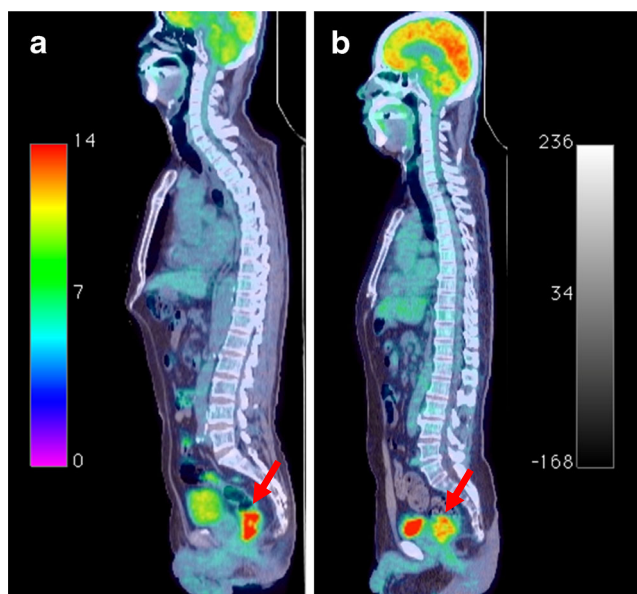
Representative pretreatment [^{18}F]FDG PET/CT images. a A 75-year-old man with cT3N2M0 rectal cancer who had undergone nRCT with capecitabine. After surgery, the pathological stage was ypT3N1M0 with a negative circumferential resection margin and perineural involvement. He received adjuvant chemotherapy, and showed no evidence of disease for 21 months after initial diagnosis. The PET/CT image shows a primary rectal cancer lesion with homogeneous FDG uptake (arrow). b A 56-year-old man with cT3N2M0 rectal cancer who had undergone nRCT with capecitabine. After surgery, the pathological staging was ypT3N0M0 with a negative circumferential resection margin. He received adjuvant chemotherapy, but developed liver metastasis 8 months after the initial diagnosis. The PET/CT image shows a primary rectal cancer lesion with heterogeneous FDG uptake (arrow), for which GrKurtosis was high
